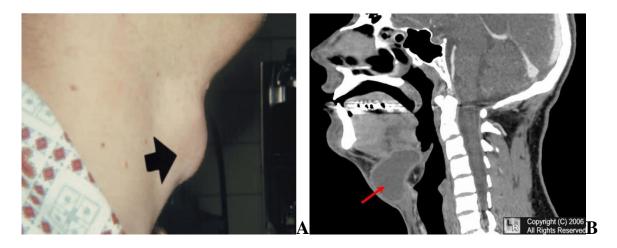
A-Thyroglossal duct cyst. Swelling (arrow) of the anterior midline of the neck. (Neville et al, 2009) B-Reconstructed CT scan of the neck demonstrates a
